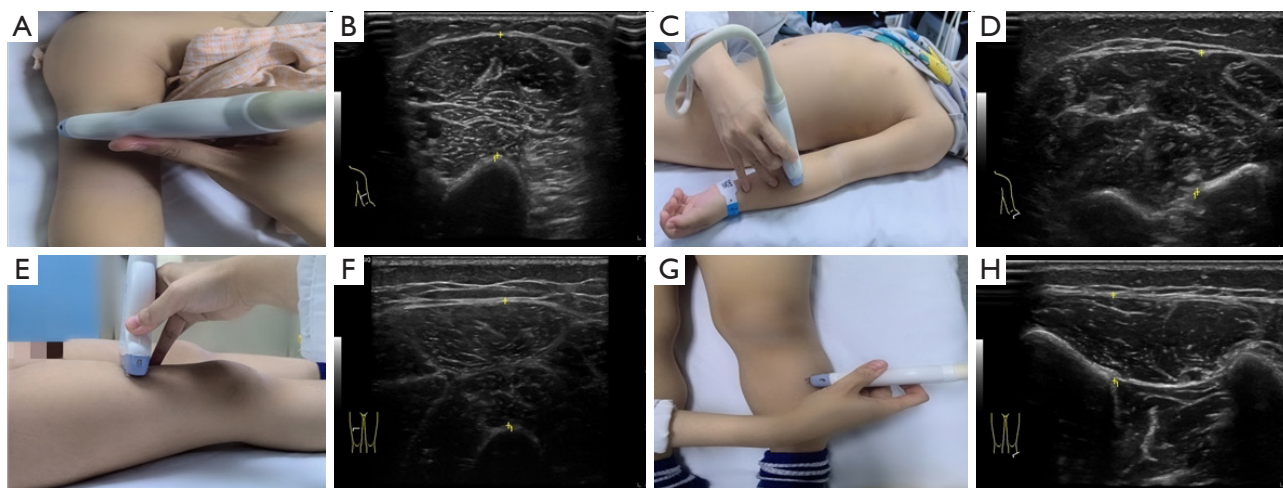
The measurement positions for the ultrasound examination of the limbs. (A,B) Biceps brachii: the biceps brachii is measured at two-thirds of the distance from the acromion to the anterior fold of the elbow. (C,D) Brachioradialis: the brachioradialis is measured at two-fifths of the distance from the anterior aspect of the olecranon to the distal end of the radius. (E,F) Quadriceps femoris: the quadriceps femoris is measured at half the distance from the anterior superior iliac spine to the upper border of the patella. (G,H) Tibialis anterior: the left tibialis anterior is measured at one-fourth of the distance from the inferior aspect of the patella to the lateral malleolus.
